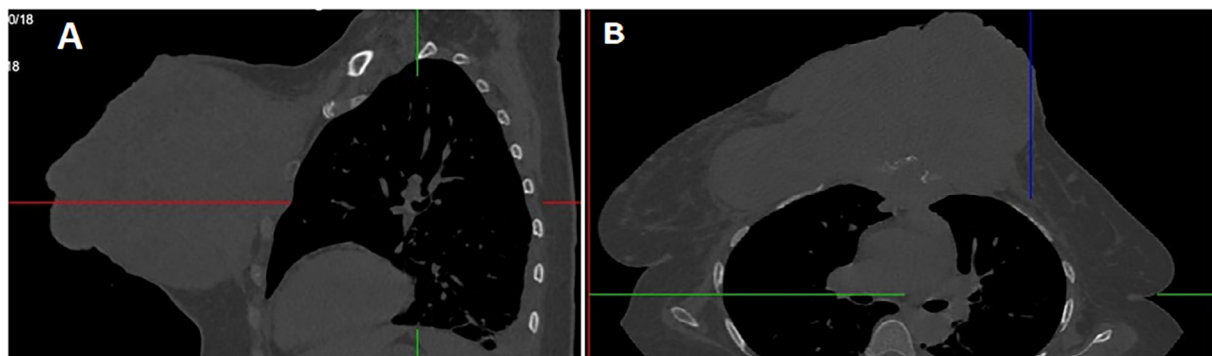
(A) Coronal Reformat of chest CT scan show a huge hypodense soft tissue mass with irregular margins attached to the muscular layer of the chest wall (B) Axial section of the chest CT scan showing a huge hypodense soft tissue mass within the muscular layer of the anterior chest wall with underlying sternal invasion.
